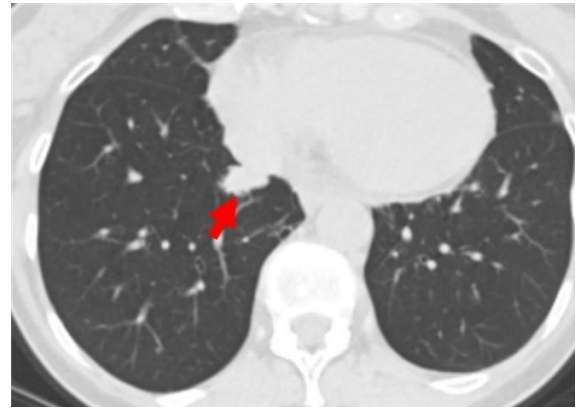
Repeat CT scan showed an increase in the size of the RLL nodule (red arrow). To view figure 3 in a separate, enlarged window click [here](#).
